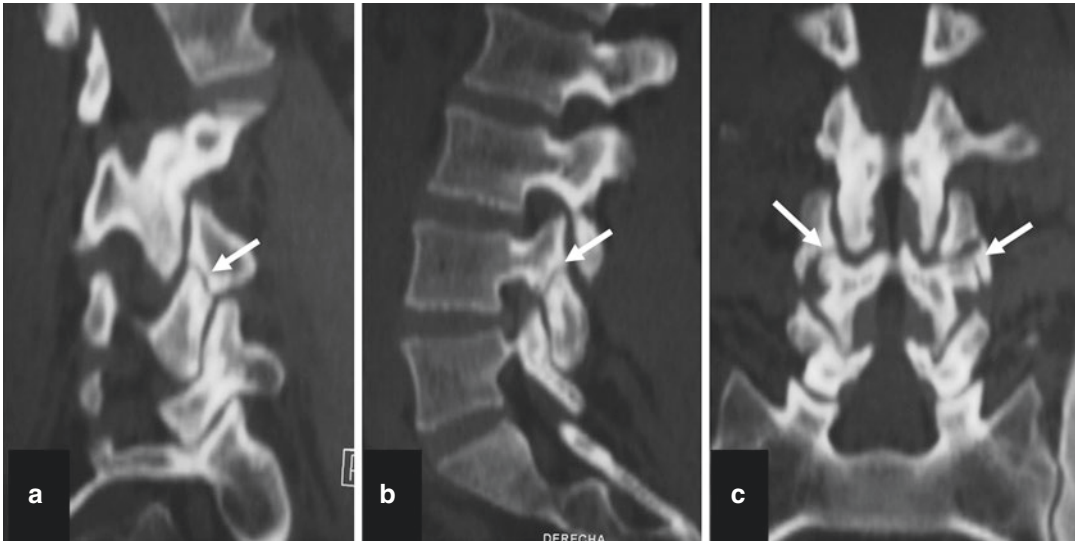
Obliquely (a), sagittally (b) and coronally (c) reconstructed CT of the lumbar spine shows a defect of the pars interarticularis on the L4 (arrows). In coronal view is visible bilateral injury
